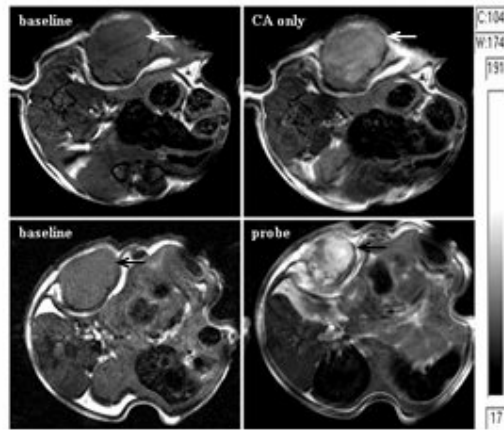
Comparison of the signal enhancement by CA alone (panels A-B) and by the probe TfNIR-LipNBD-CA (panels C-D). The MR images are from the same tumor with an interval of 72 h between studies with the probe and with CA alone. A stronger and heterogeneous signal enhancement is achieved with TfNIR-LipNBD-CA over CA alone. The MRI parameters are the same as for Fig. 3.
